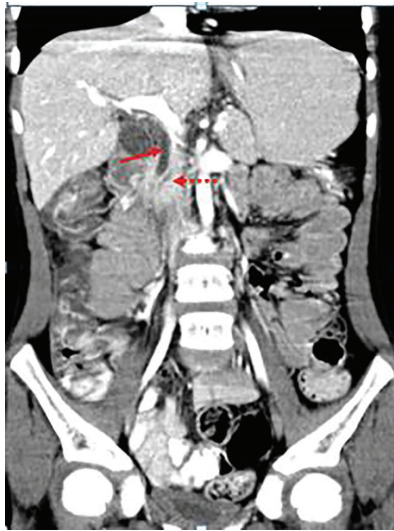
Coronal image of abdominal CT scan with IV and oral contrast shows dilation of common bile duct (straight arrow) and pancreatic duct (dotted arrow)
